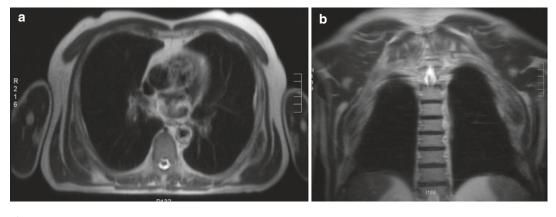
(a, b) Bilateral elastofibroma dorsi. (a) Axial TSE T2-weighted MR image; (b) coronal TSE T2-weighted MR image. Elastofibroma dorsi has a typical multilayered morphology, consisting of alternating bands
